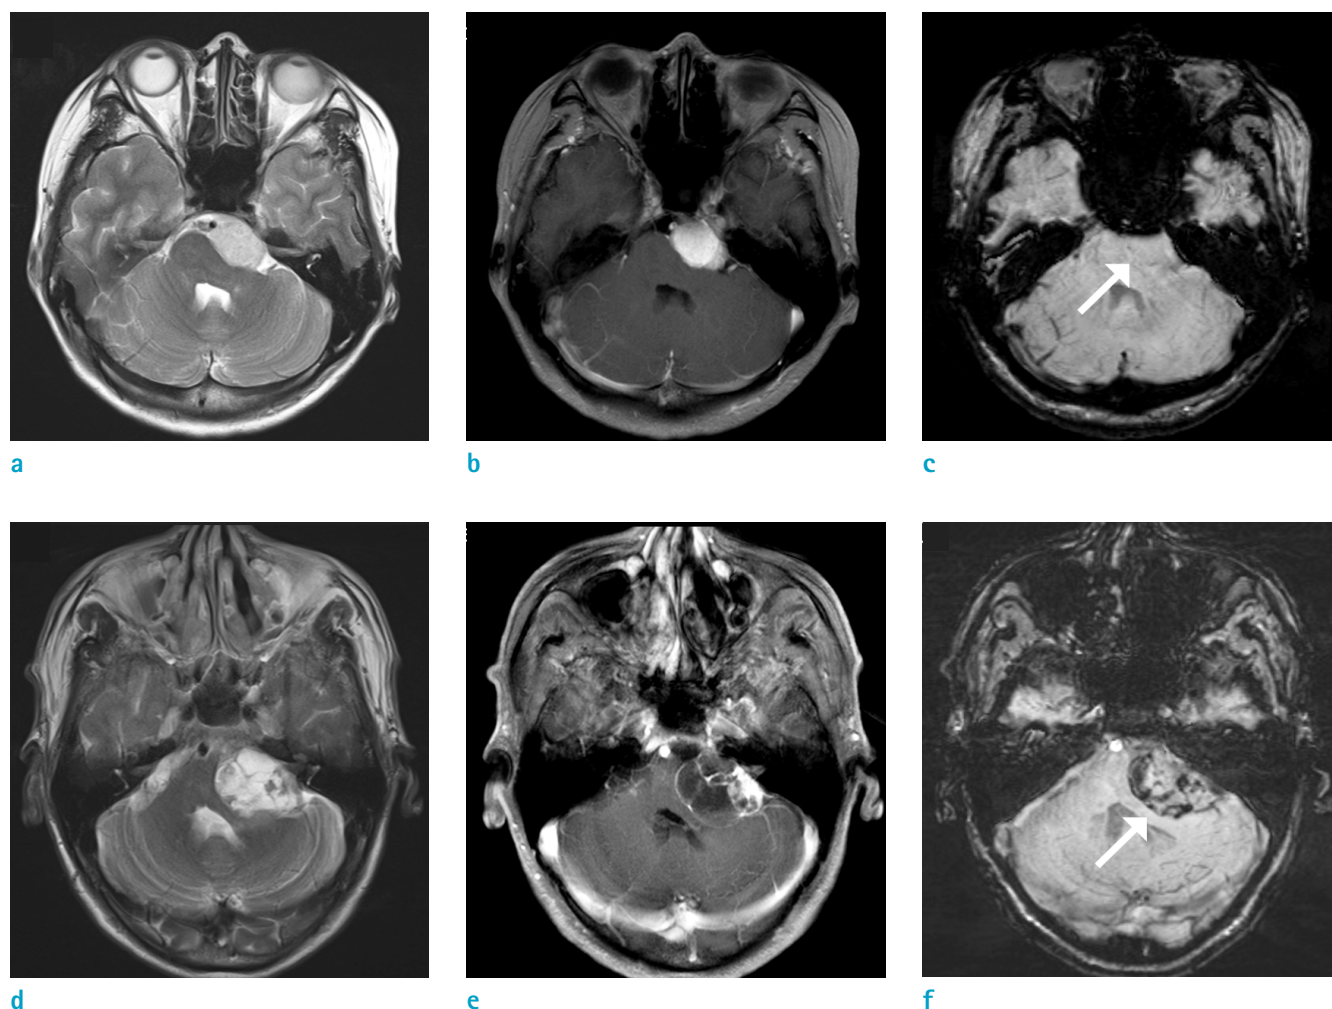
Representative images of meningioma (upper row) in a 35-year-old woman and schwannoma (bottom row) in a 66-year-old male. From left to right, each column represents T2-weighted (a, d), contrast-enhanced T1-weighted (b, e) and SWI (c, f) of tumor located in left cerebellopontine angle. Schwannoma shows punctate dark signal intensities on SWI (f) while meningioma shows none (c) (arrows). SWI = susceptibility-weighted image.
